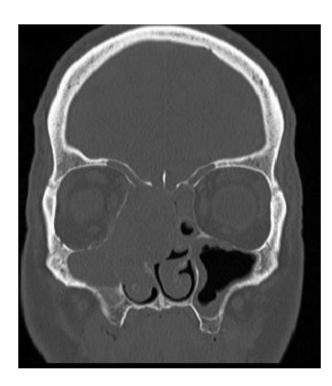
Coronal image of CT paranasal sinus (bone window) shows bony remodeling of right lamina papyracea, cribriform plate, anterior-superior nasal septum and medial wall of right maxillary sinus by mass lesion. This osseous remodeling reduces intraorbital volume, accounting for the patient's right proptosis.
